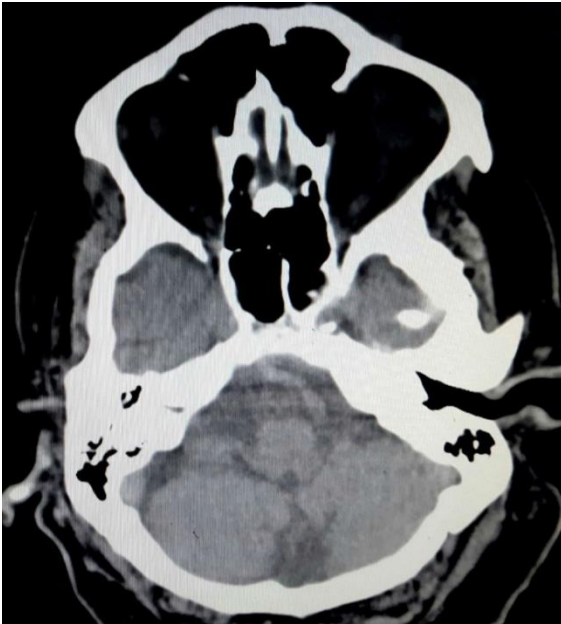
CT scan (in 2018) for the brain which shows a calcified basilar artery (brain window). The scan was affected by beam hardening artefact.
